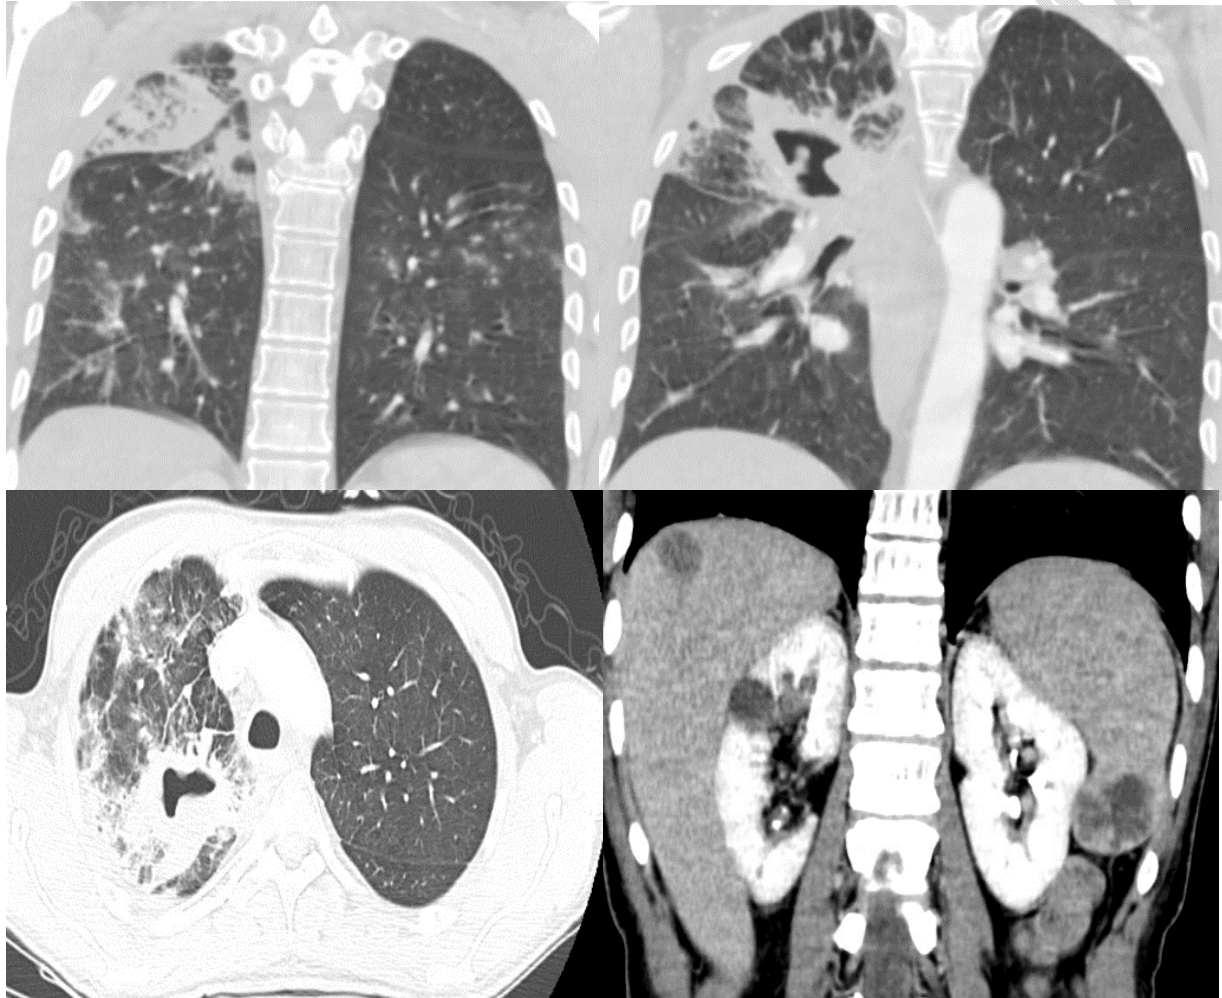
CT scan at presentation
